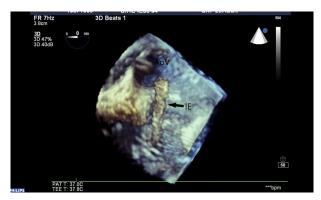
Case 2: 3D transesophageal echocardiographic image of infective endocarditis (IE) mass from atrial side. *AoV*, Aortic valve.
